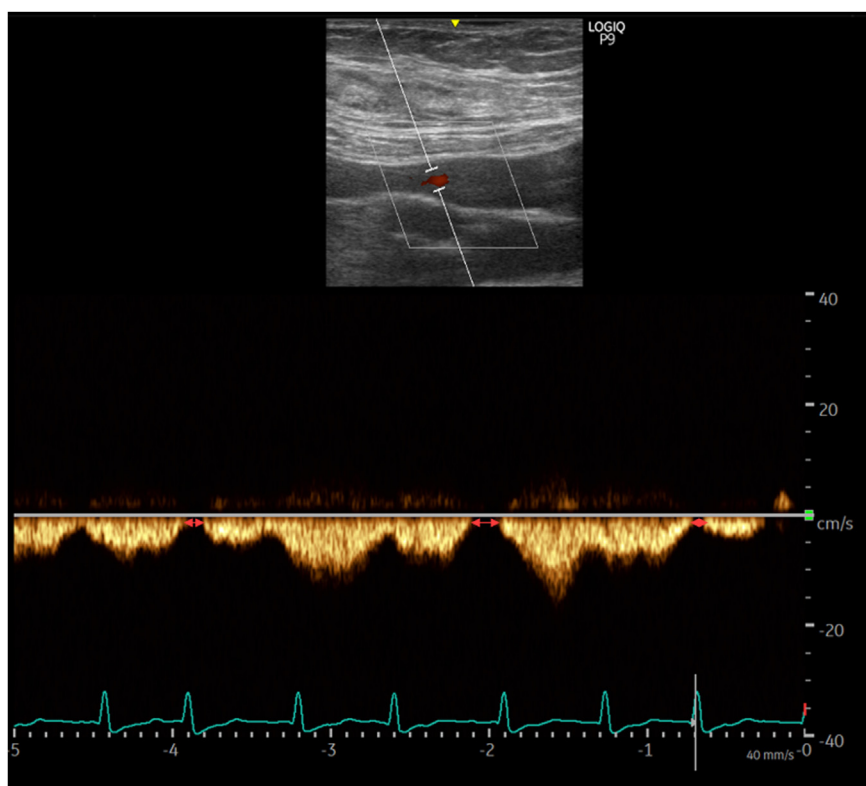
Serial 2D-guided color-flow and pulsed-wave Doppler, subcostal, hepatic vein (A), and right lateral decubitus, portal vein (B), spectral displays after 2.5 L ultrafiltration, demonstrates persistent S-wave flow reversal and relatively normal portal vein wave-form with minimal pulsatility, respectively.
